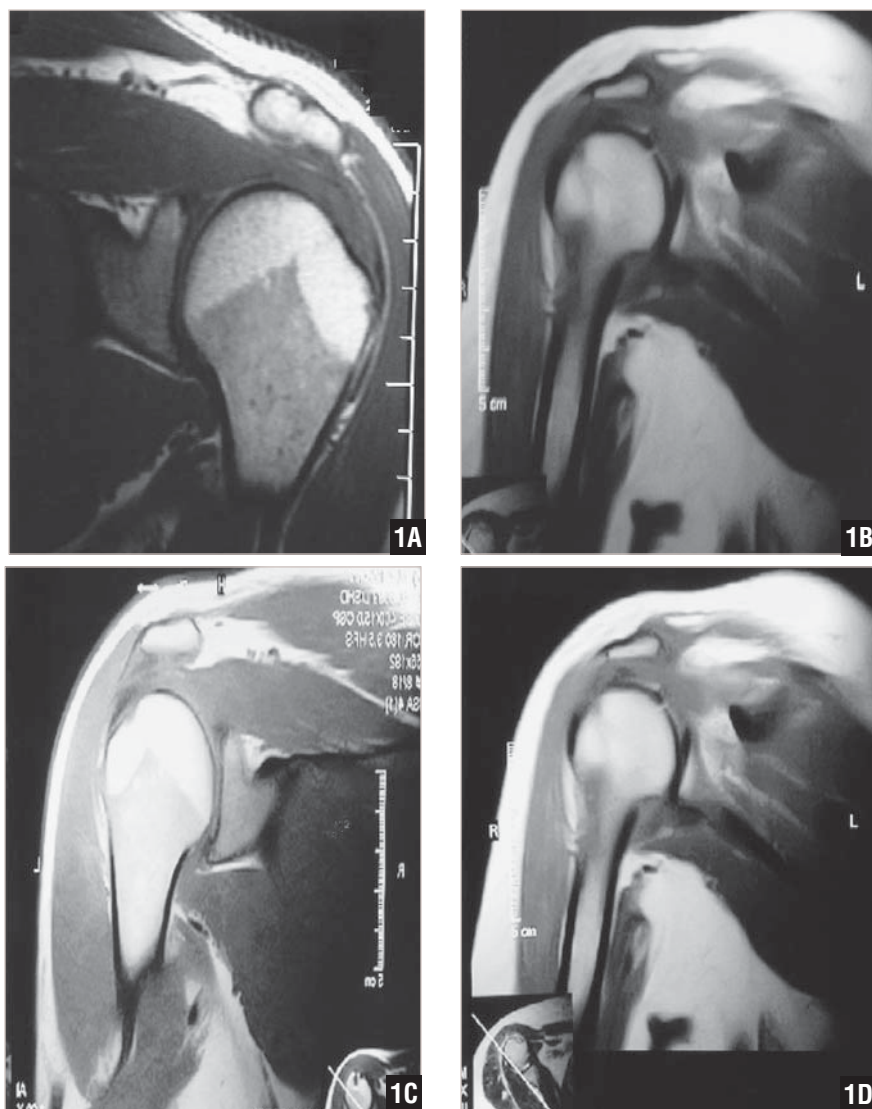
Representative preoperative coronal T1-weighted MRI of the shoulder (A). Representative postoperative MRIs from the electrocautery (B), monopolar RFE (C), and bipolar RFE (D) demonstrate no evidence of bony edema or osteonecrosis of the acromion.
